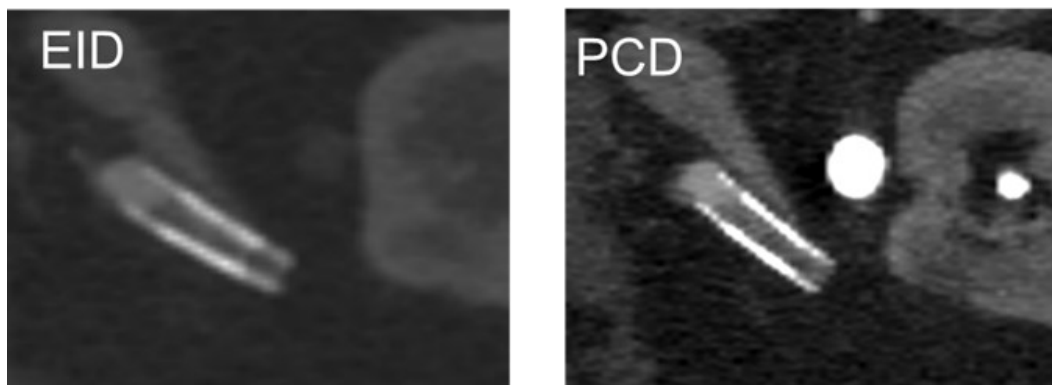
Improved visualization of left renal artery stent using PCD-CT (right) in comparison with EID-CT (left), which has significant in-stent stenosis and left renal infarction.
